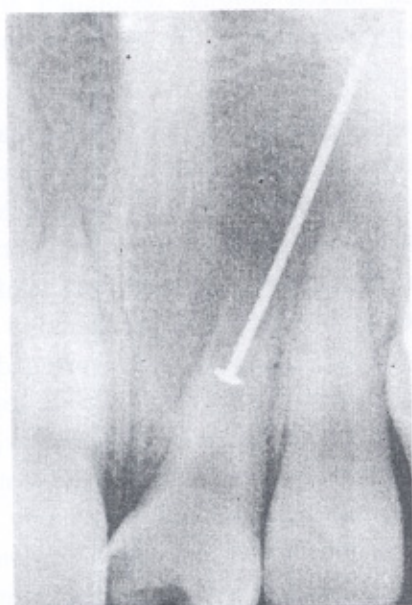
Pre-operative radiograph shows periapical lesion around the apex of tooth # 21. Note the pin extending beyond the apex of the root.
